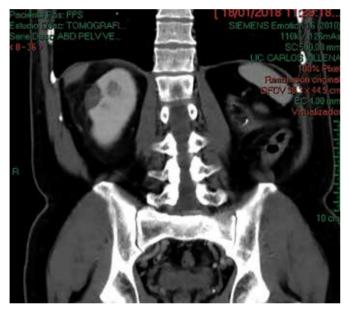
Urotomography (Uro-CT) coronal section, in venous phase.
